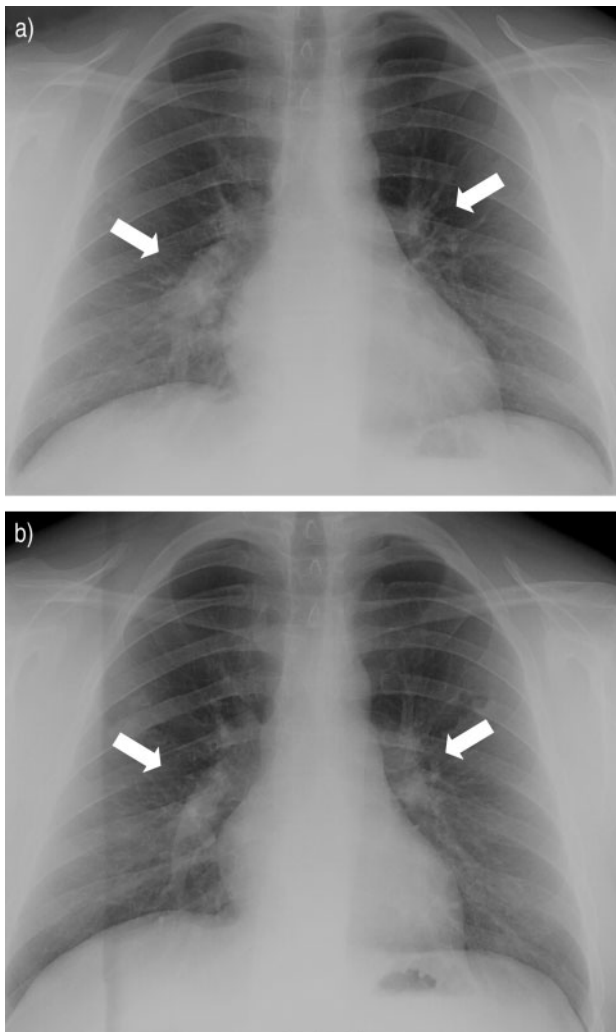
Hilar enlargement (arrows) in a 24-yr old farmer (case number 1) with fever but with no lower respiratory tract symptoms. Radiography was performed a) 13 days and b) 10 weeks after onset of disease.
